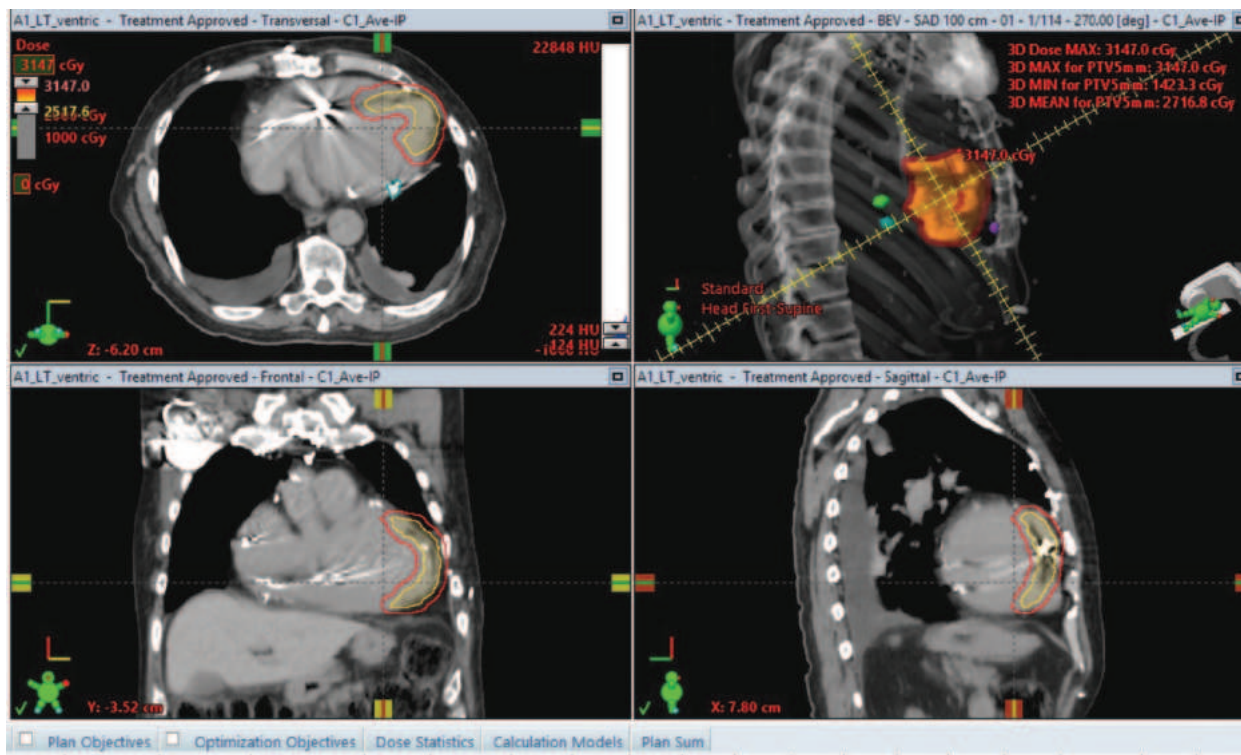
Stereotactic body radiation therapy. Shown is a planning computed tomography scan for noninvasive cardiac ablation delivered with stereotactic radiation. The region of interest is determined by analysis of presenting arrhythmias, underlying structural heart disease, and proximity to adjacent structures such as coronary arteries, the phrenic nerve, and the gastrointestinal tract. Radiation is delivered to the chosen treatment volume in order to create conduction block in the culprit scar region.
